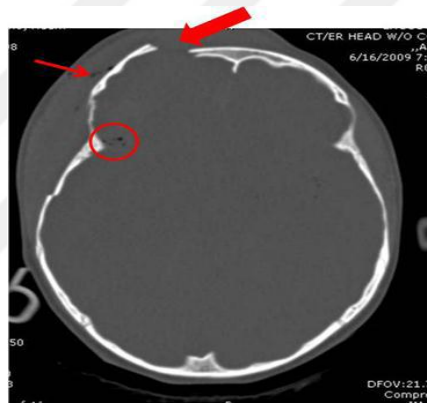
CT Brain Linear Skull Fracture [29].
